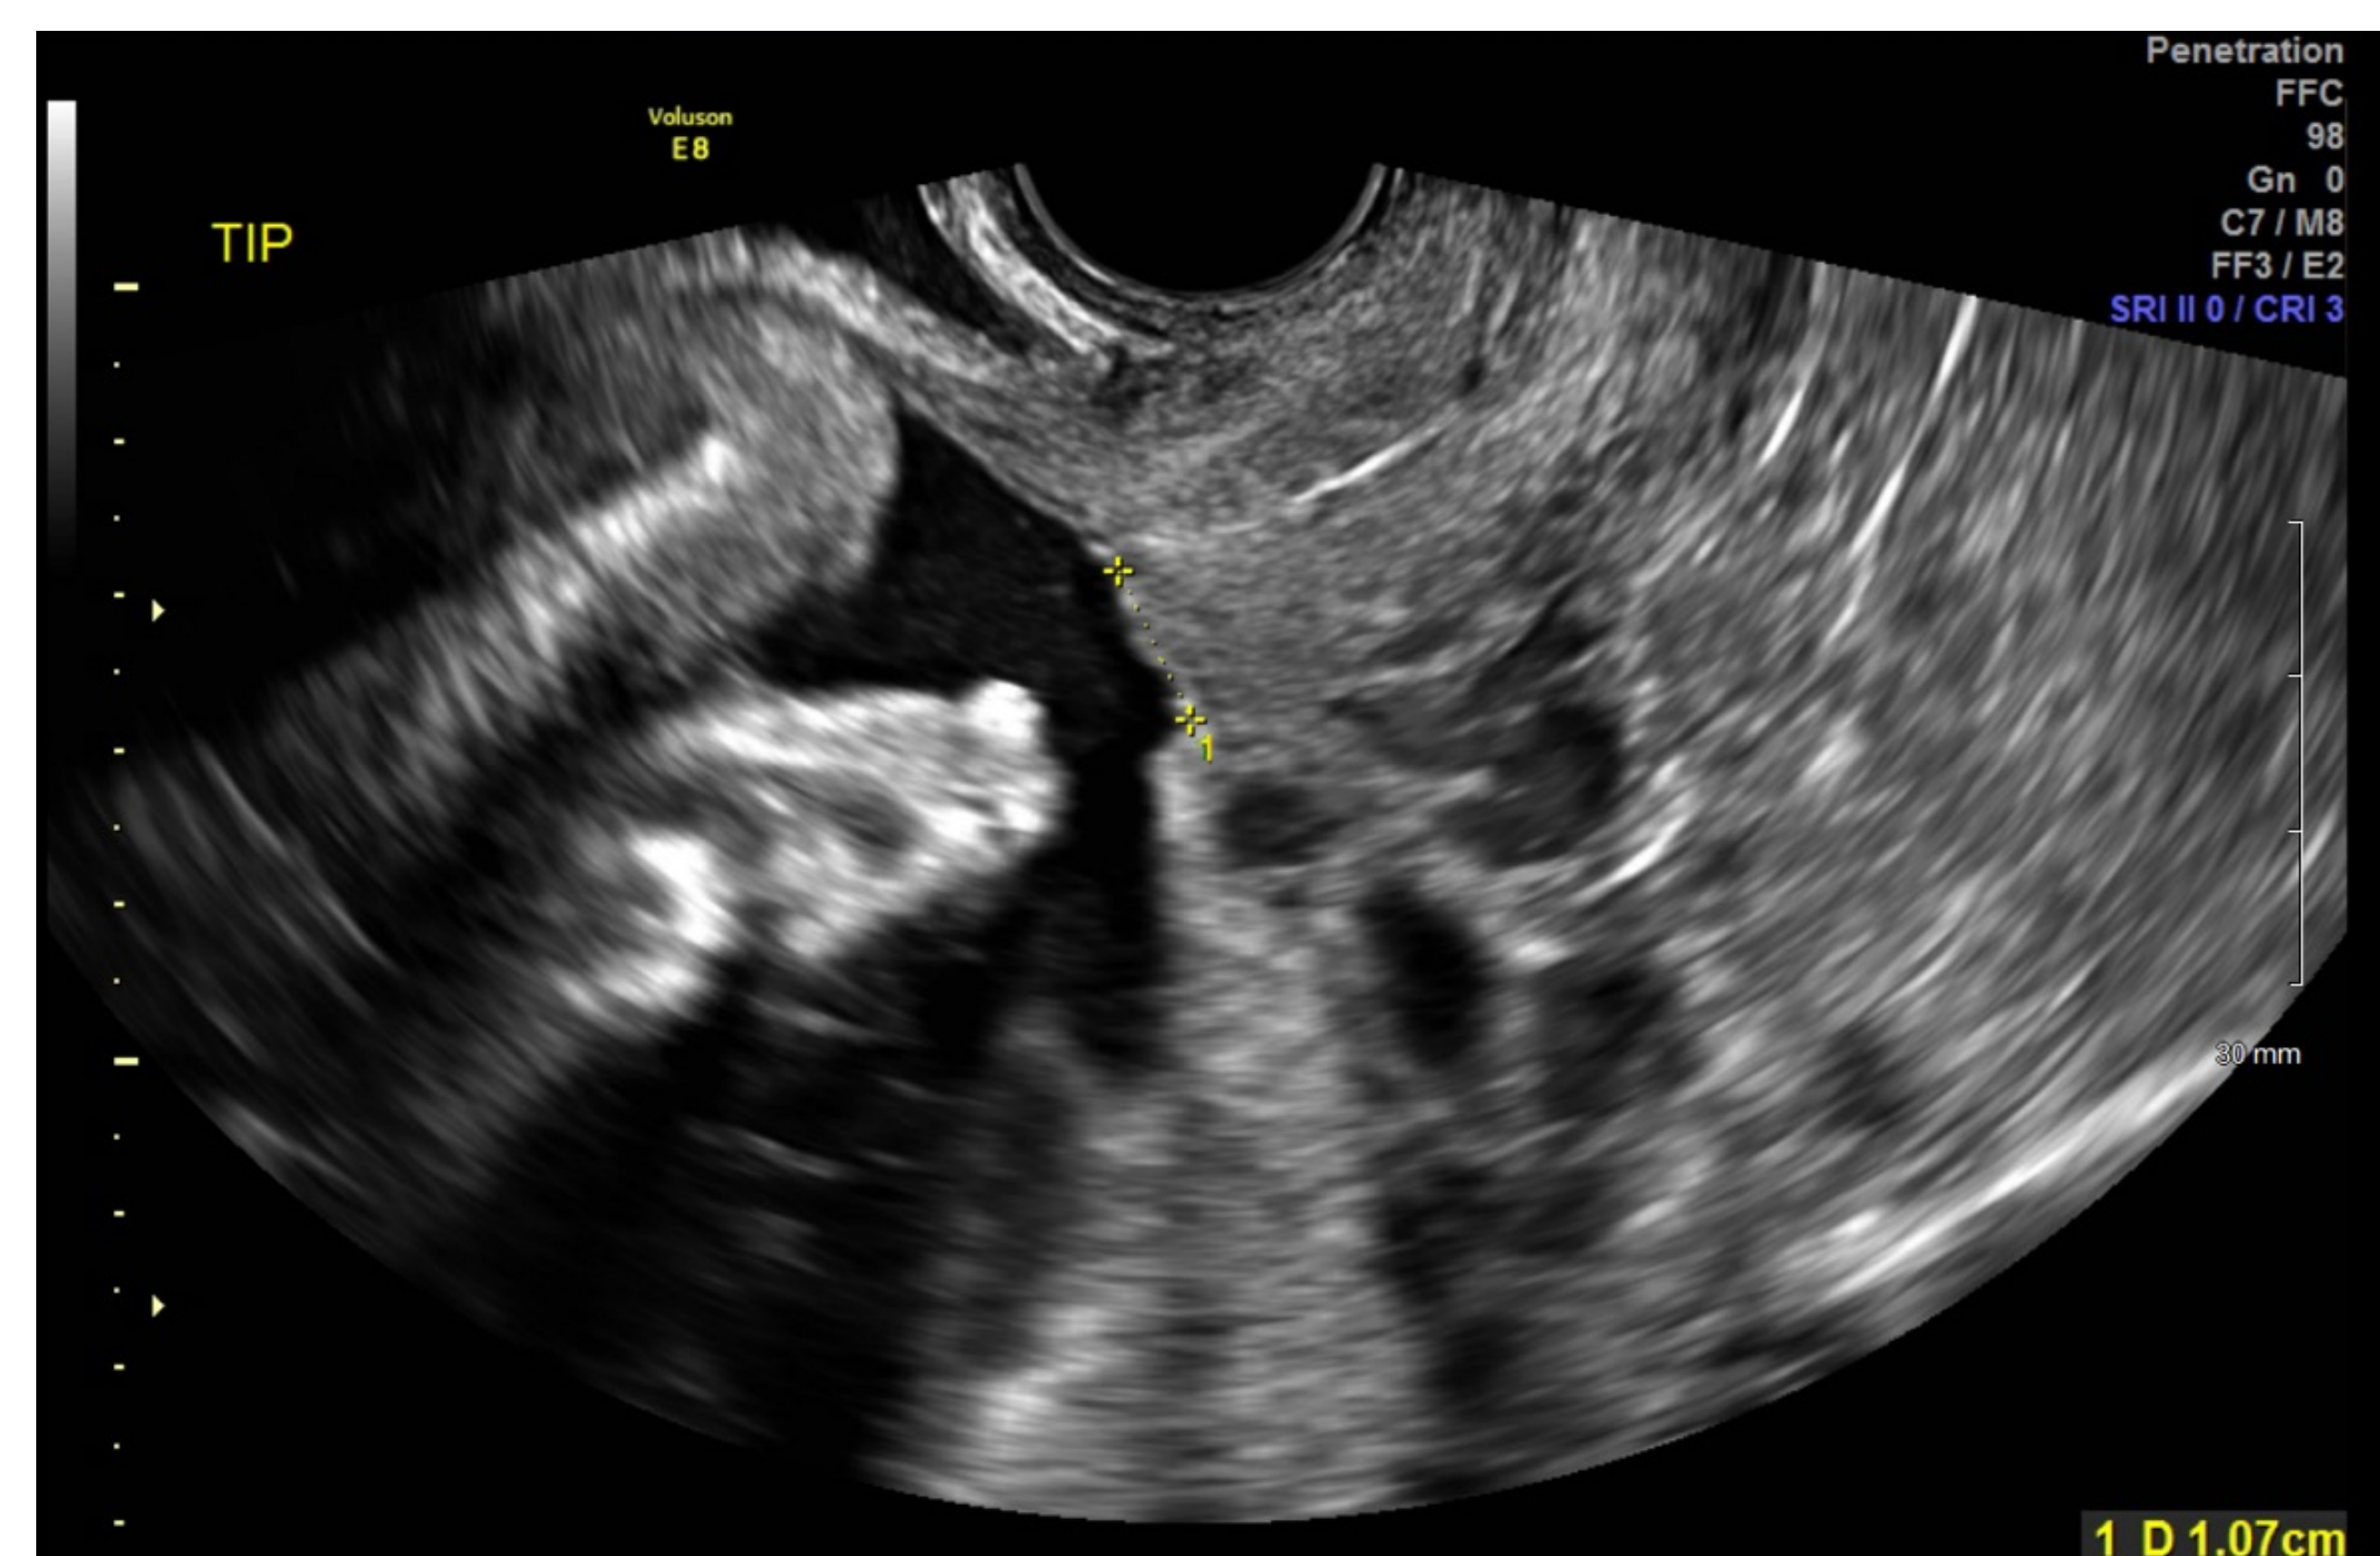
Ultrasound image of left lateral low-lying posterior placenta 1.07 cm from internal cervical os on 32.4 week growth ultrasound
